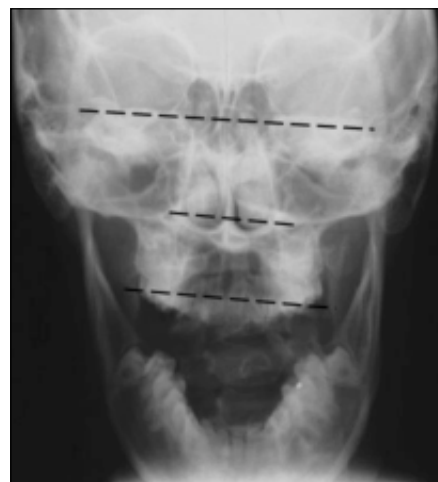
Anteroposterior Skull Radiograph of Right Torsion patient K.F.
